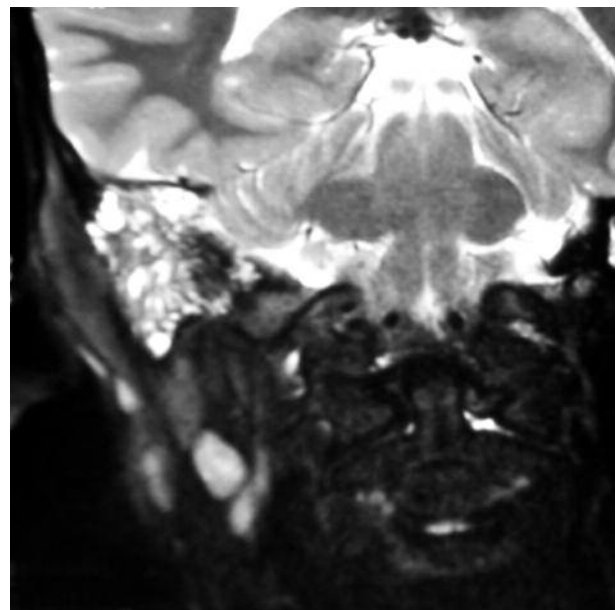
Coronal T2-weighted image shows hyperintense material in the right mastoid cells)
